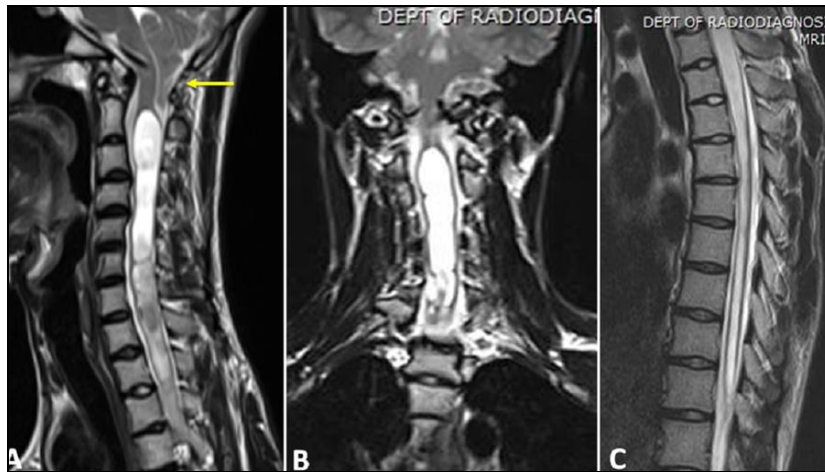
Arnold chiari malformation type I with syringomyelia: T2W Sagittal and Coronal MRI images show descent of cerebellar tonsils below the foramen magnum causing cervico-medullary junction stenosis and T2 hyperintense long segment syrinx formation with cord expansion involving nearly the whole length of spinal cord.
